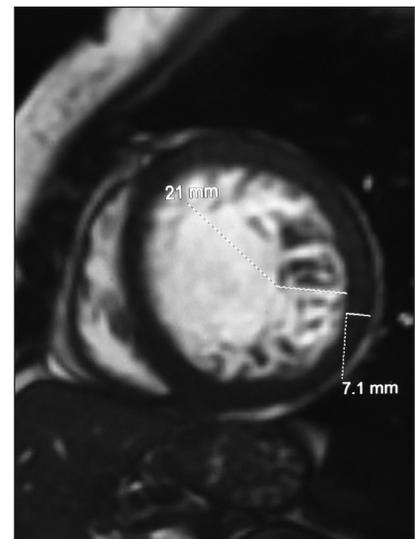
Cardiac magnetic resonance image showing short-axis of left ventricular apical myocardium. Compacted myocardium was 7.1 mm (bottom dashed line), and the noncompacted myocardium was 21 mm (top dashed line), resulting in a noncompacted-to-compacted ratio of approximately 3.0.
